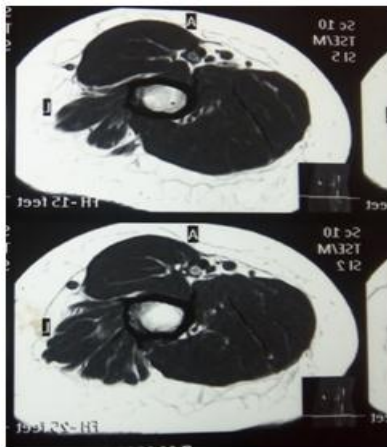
B): MRI right arm showing typical appearance of cysticercus with scolex inside.
